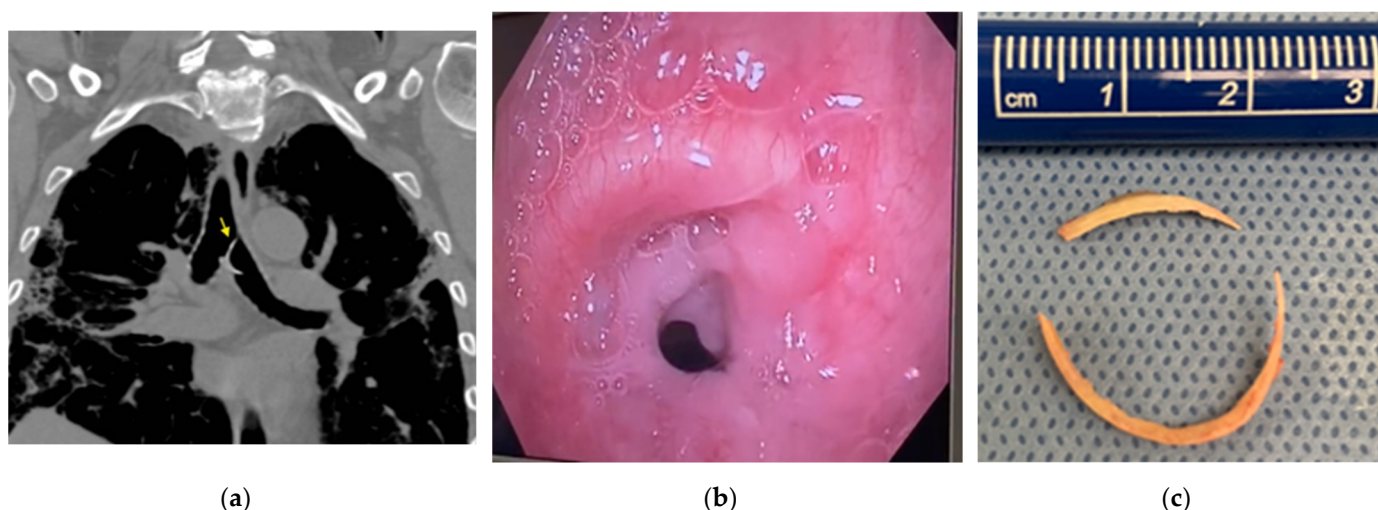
(a) SGS occurring at the cricoid cartilage, which was fractured and is protruding into the airway lumen (yellow arrow); (b) non-contrast chest CT scan, coronal view showing a curvilinear hyperdense foreign body in the proximal left mainstem bronchus marked with arrow; (c) gross appearance of foreign body.
